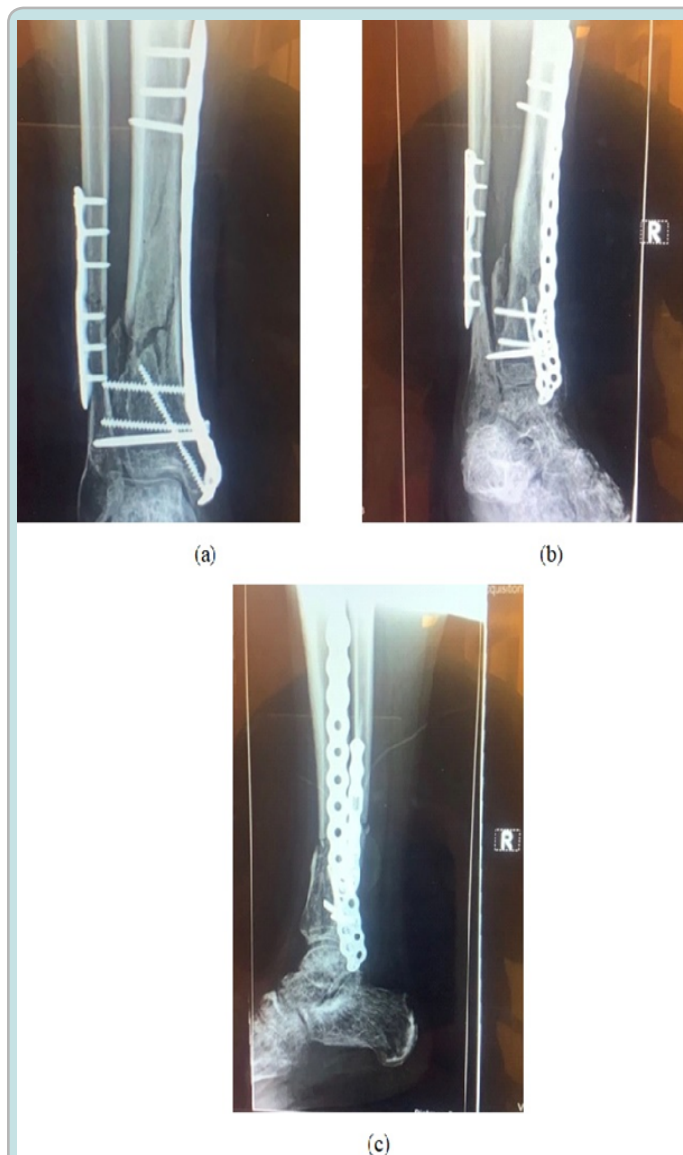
X-rays (a,b,c) captured before the initiation of fESWT.
